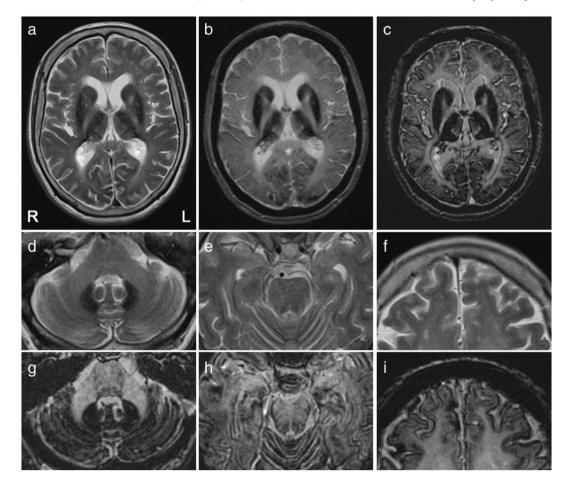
Brain MRI. (a) A T2-weighted axial image showing hypointensity in the bilateral basal ganglia and thalamus, which is typical for ACP. (b) A T2*-weighted axial image showing more clearly recognizable hypointensity than the T2-weighted image (T2WI). (c) A susceptibility-weighted axial image (SWI) clearly showing hypointensity at the surface of the entire cerebral cortex, in addition to the bilateral basal ganglia and thalamus.T2WI (d–f) and SWI (g–i) at the cerebellum (d, g), pons (e, h), and frontal lobe (f, i). Hypointensity rims without laterality are evident at the cerebellar folia, pons, and the surface of the frontal cortex.
